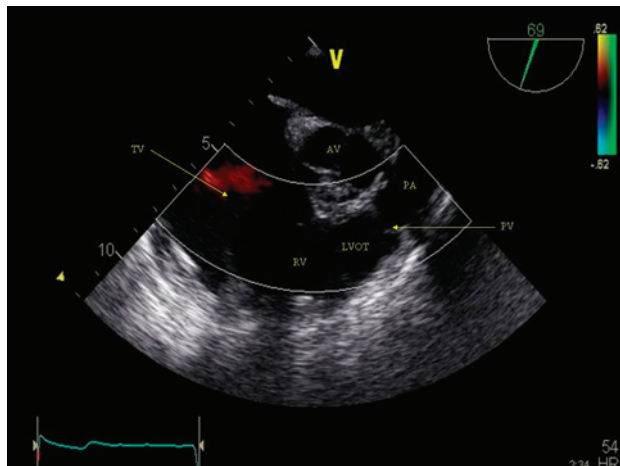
Mid-esophageal right ventricular inflow-outflow with colorflow Doppler.
